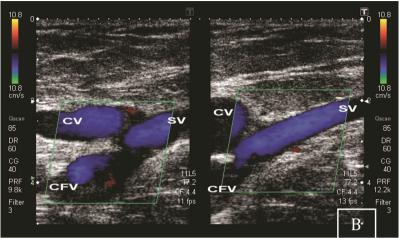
Clinical examination (A) revealed visible subcutaneous veins at the left inguinal region. Duplex-ultrasound scan (B) revealed thrombosis of the left iliac and common femoral vein (CFV), with intensive vein flow through the saphenous vein (SV) and subcutaneous collaterals (CV).
